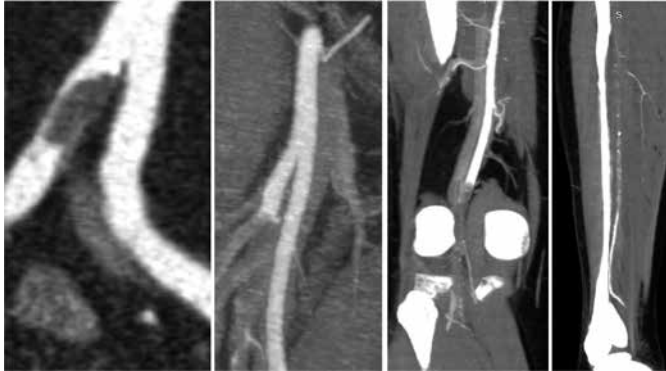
CTA of the aorta and the lower limbs depicting partial thrombosis of the right common iliac artery and complete thrombosis of the right profunda femoral, right popliteal and the right posterior and anterior tibial arteries.
